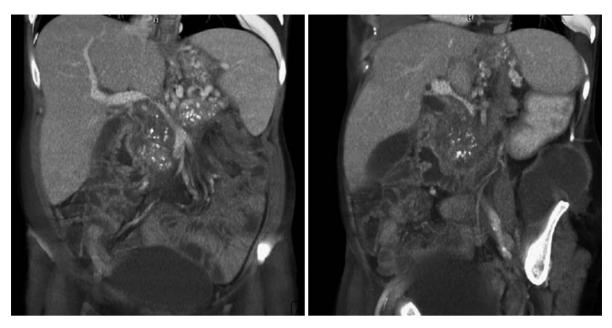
A 44-year-old woman with known chronic pancreatitis due to alcohol abuse is referred to CT for pain and tender mass in the left flank. Her BMI is 23.6 kg/m². Enhanced MDCT of the abdomen with one phase was obtained during the portal vein phase. Pancreatic calcifications, portal vein stenosis, and gastric varicose are demonstrated on a coronal VRT reformation (*left image*) and an abscess is demonstrated in the left flank (*right image*). The acquisition was performed with 16×0.6 mm collimation, 110 kVp, and a reference effective mAs (representing the image quality index) of 90 mAs. This image quality index is 30% lower than that recommended by the vendor for standard MDCT. For this acquisition, AEC has automatically reduced the mean mAs setting to 53 mAs. The entire abdomen was scanned with a resulting DLP of 167 mGy·cm, which corresponds to one-seventh the reference dose for CT for EUR 1999, and less than one-half of the mean dose from the UK 2003 survey
